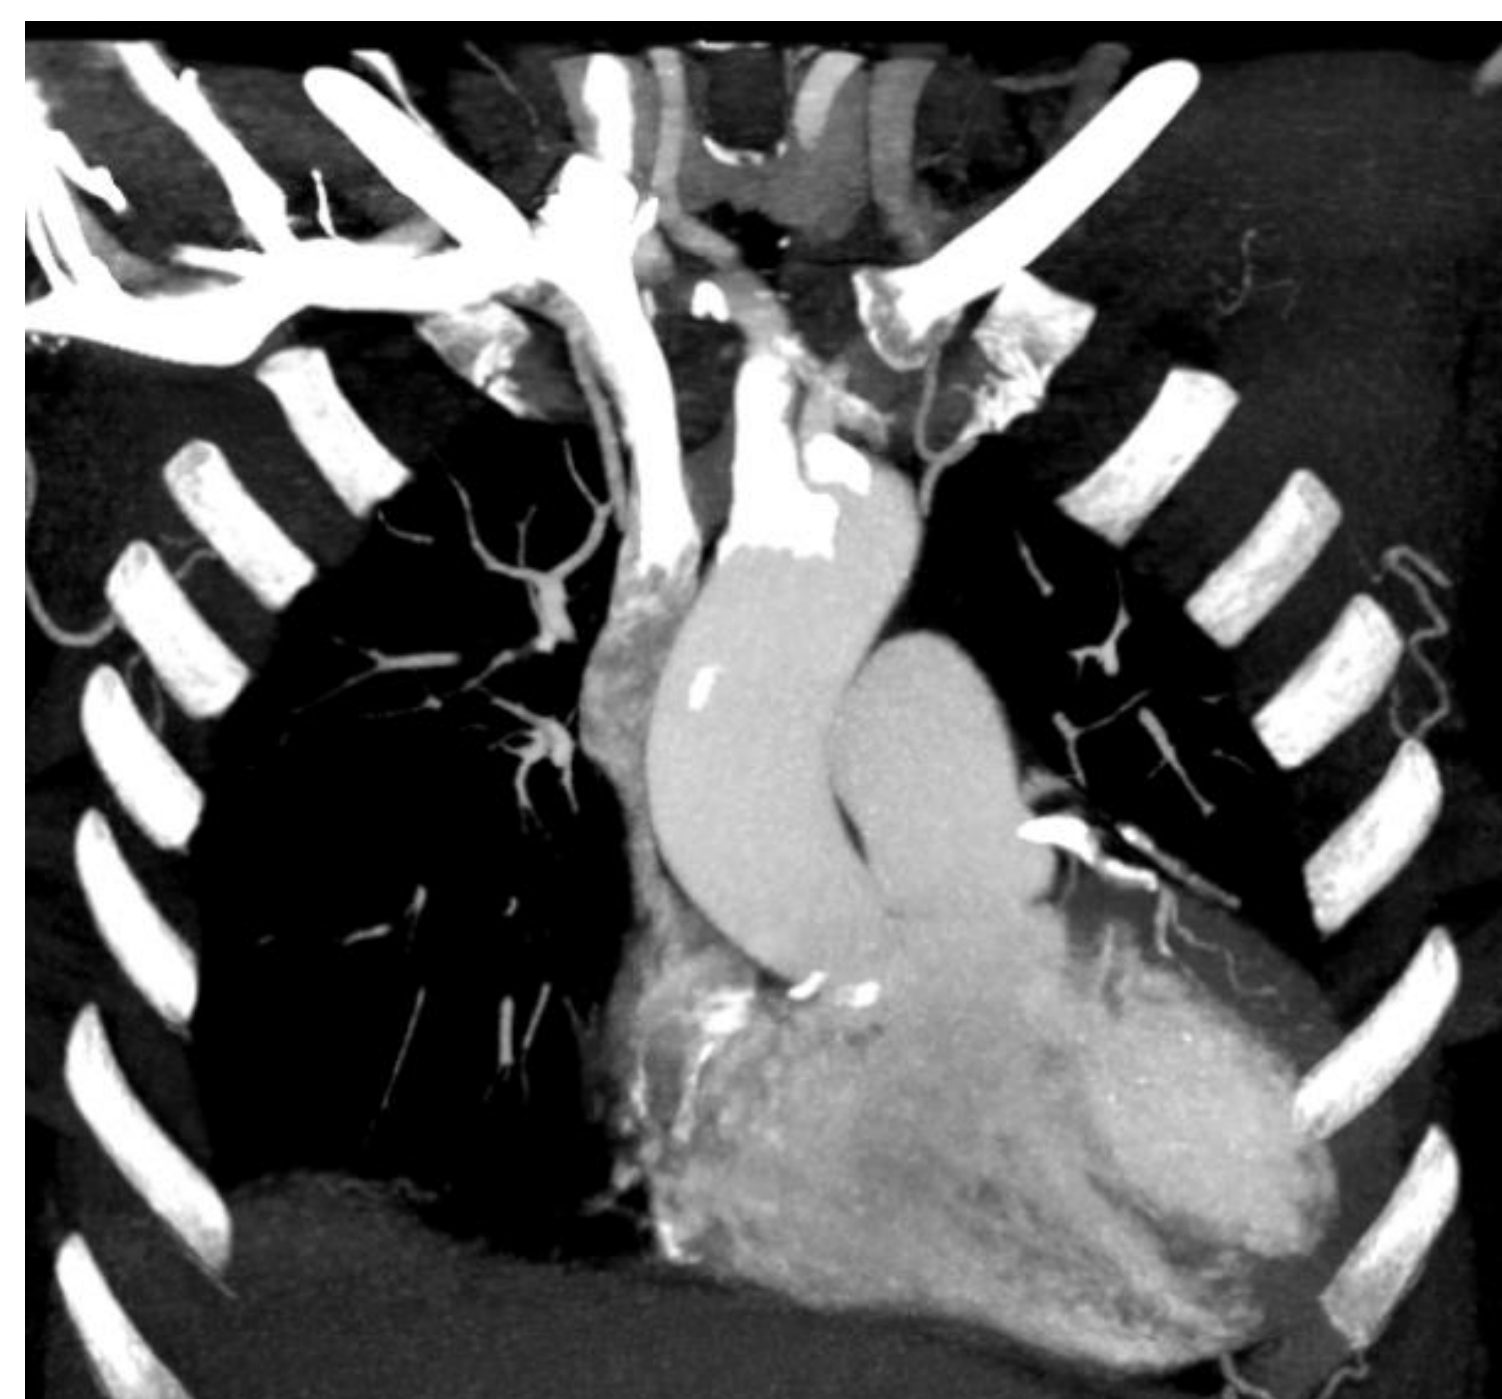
CTA demonstrating occlusion of brachiocephalic artery
